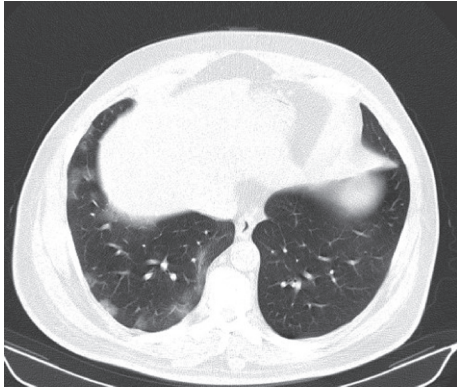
Spiral chest CT scan of the patient on day 12.
